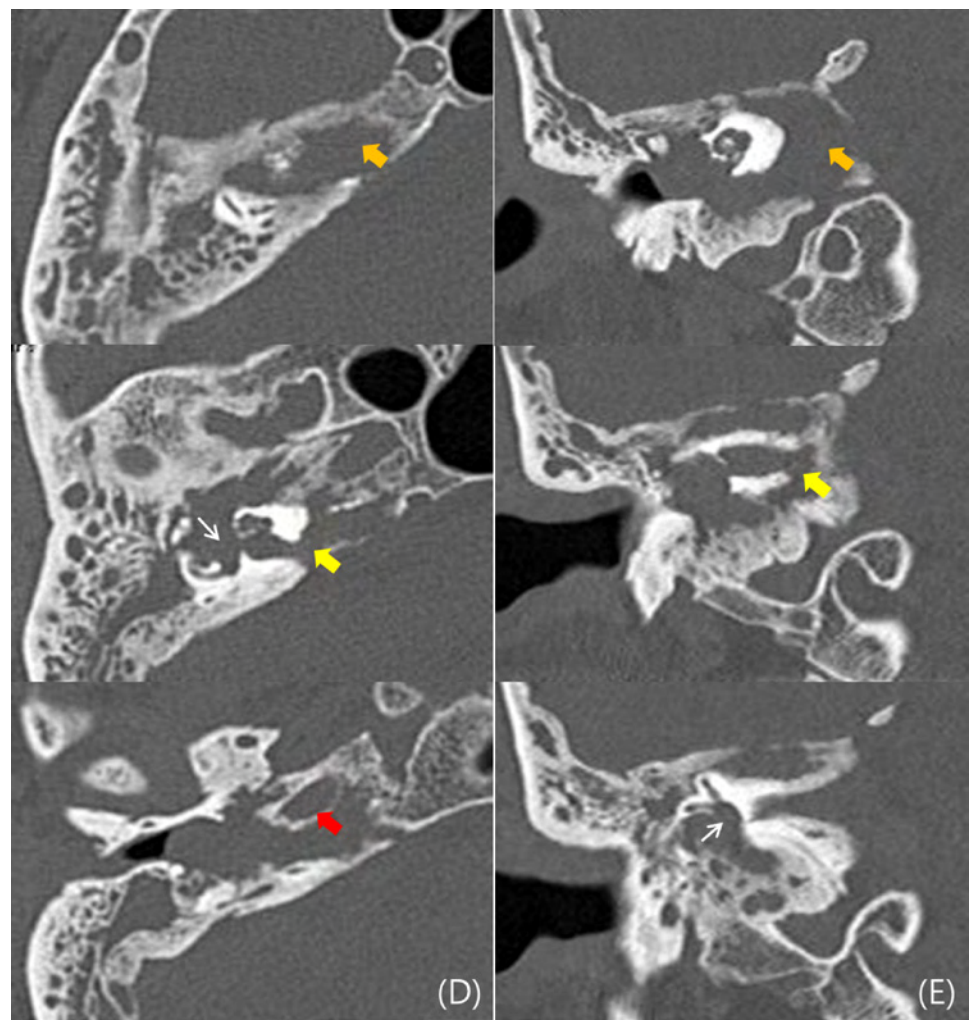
Temporal bone images. D: Axial; E: Coronal CT scan images. D, E: Computed tomography (CT) images of infiltrative soft tissue filled the middle-ear cavity and extended to petrous apex (orange arrows), erosion in medial wall of the internal auditory canal (yellow arrows), stapes and oval window destruction (white arrows), and internal carotid canal surrounded by the lesion (red arrow)
